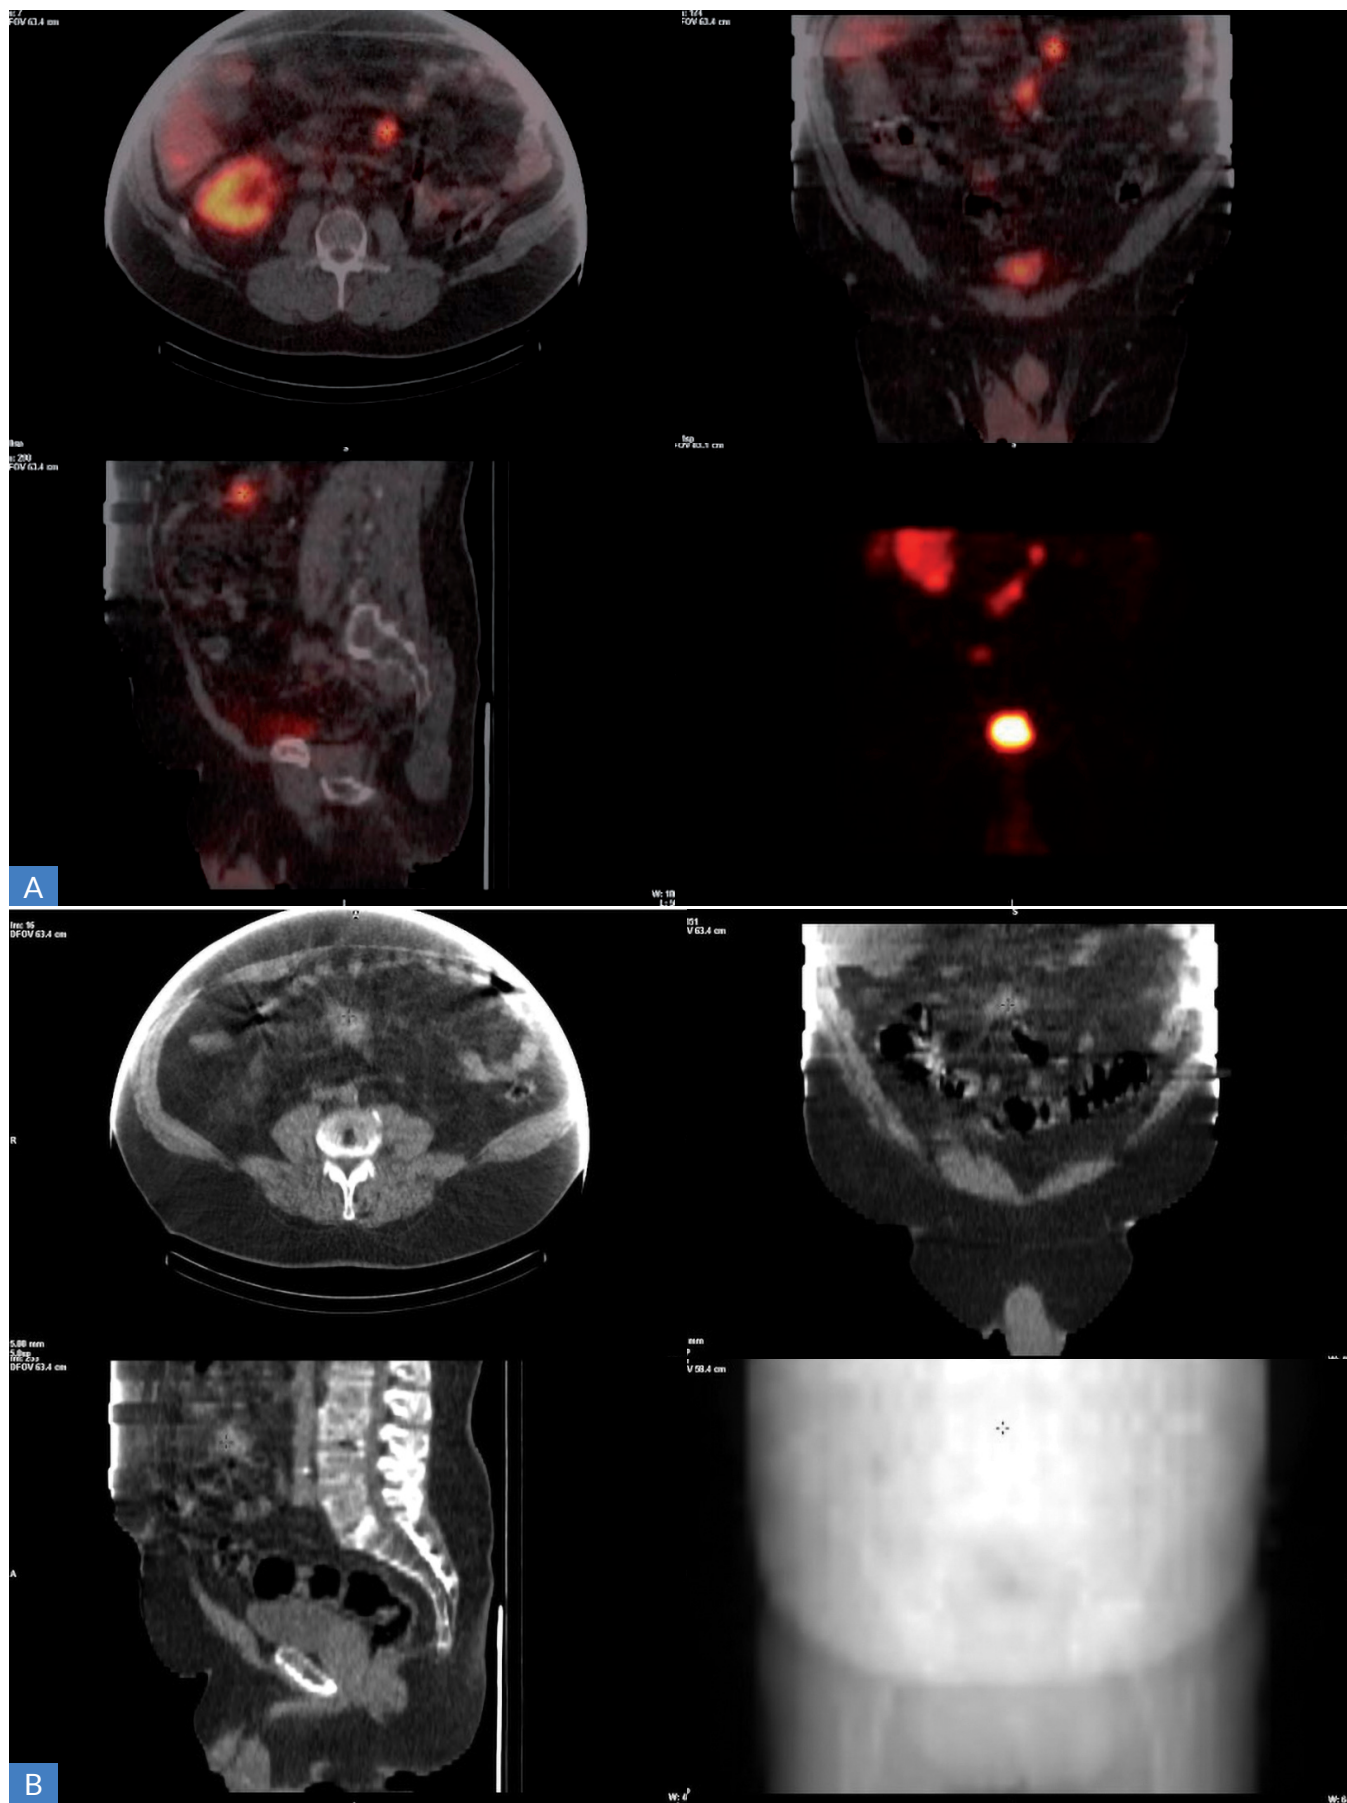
A. ^{68}Ga -PET/CT. A focal lesion in the mesentery with overexpression of type 2 somatostatin receptors was confirmed. Metastatic lesions were found in the liver, the lower pole area of the right kidney, the mesentery, mesenteric lymph nodes, small bowel and skeletal system. B. Abdominal CT. A star-shaped focal lesion causing a desmoplastic reaction with calcifications was found in the mesentery.
